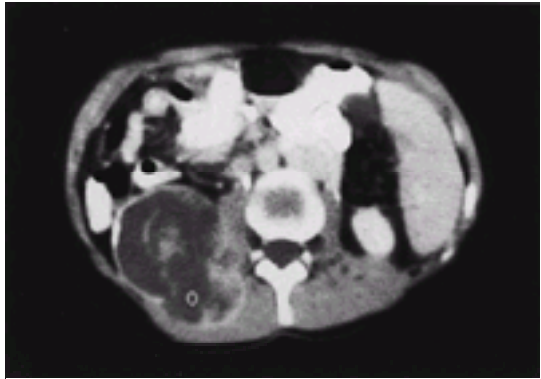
CT scan of left retroperitoneal sarcoma with invasion into paraspinal muscles.
